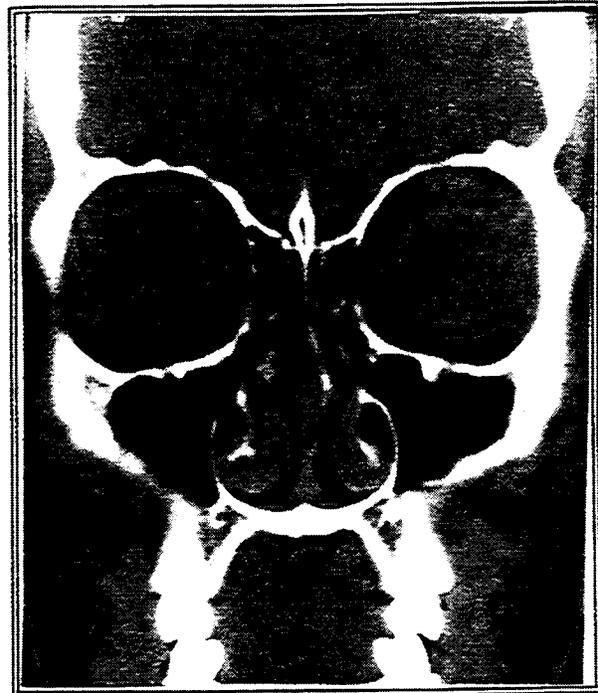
CT Scan Frontal Section of Head
